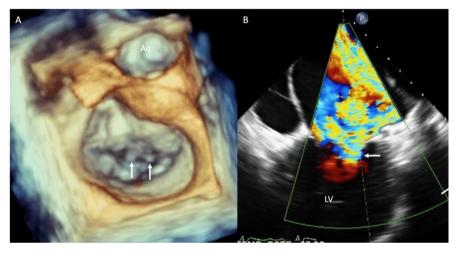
2D and 3D transesophageal echocardiogram. (A) Surgical view of the mitral valve with ruptured chordae tendineae pointed by the white arrows, (B) Color Doppler showing severe mitral regurgitation (white arrow). Abbreviations as before.
